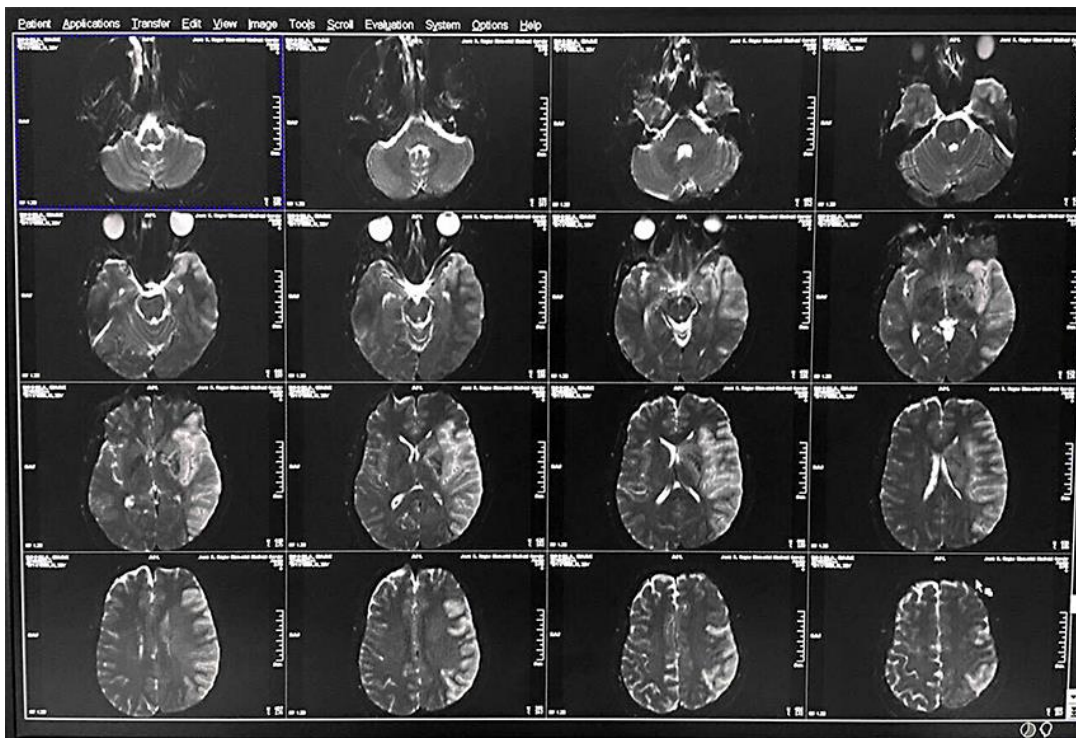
Repeat neuroimaging (MRI) done preoperatively.
